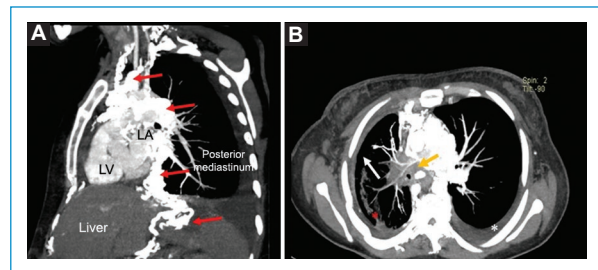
Computed tomography (CT) scan of the chest with contrast. A: sagittal view showing mediastinal conglomerate mass and collaterals of the azygos vein (red arrows). B: axial view showing a right pulmonary artery branch filling defect compatible with pulmonary thromboembolism (yellow arrow), pleural thickening (white arrow) and evidence of consolidation of the pulmonary parenchyma (asterisk).
